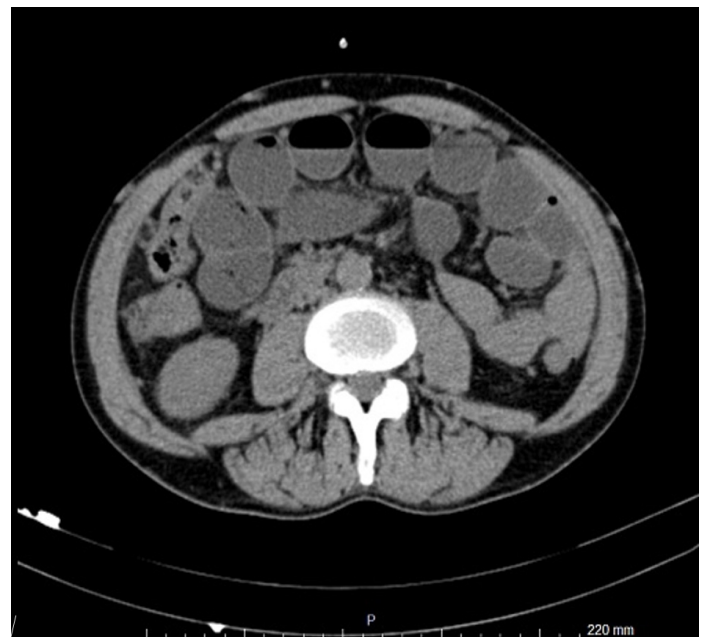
Increased intestinal segment calibrations, air-fluid levels, thinned intestinal bowel walls in CT scan
